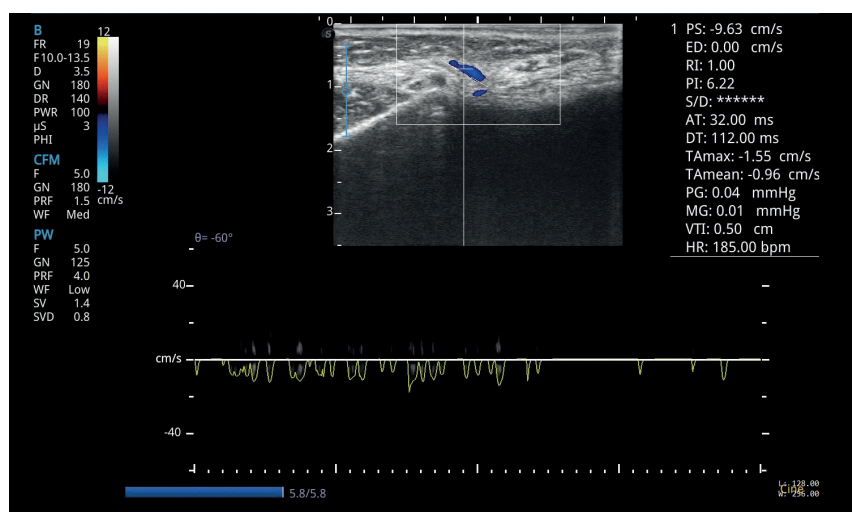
Periodontal tissues Doppler of patient B. of the main group, before treatment
